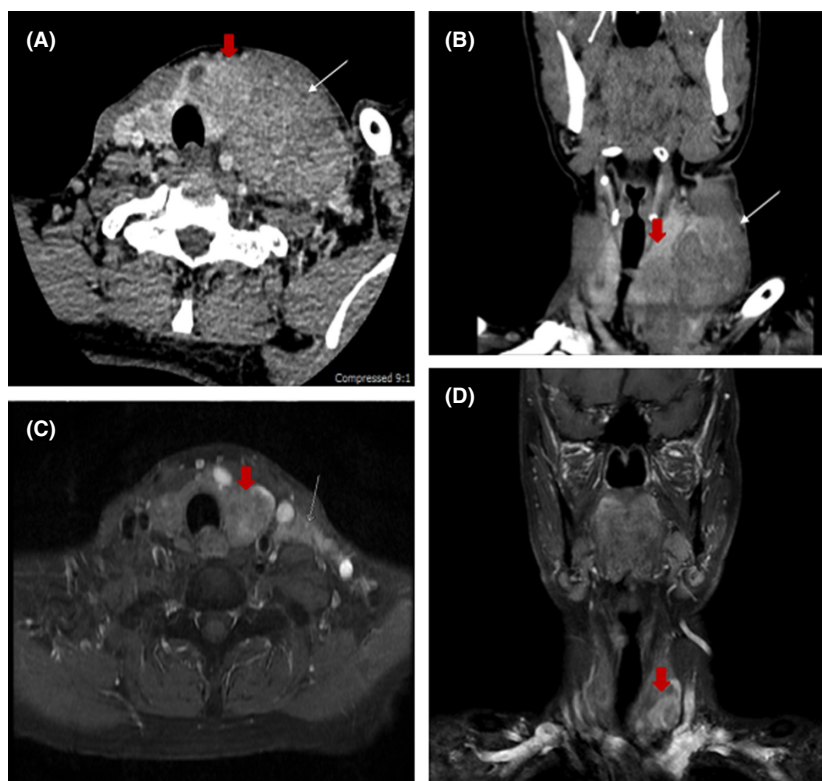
(A) Contrast CT scan of the neck; multiple hypoechoic nodules in both lobes of thyroid gland, with the largest nodules containing cystic component at lower pole of the left lobe (red arrow). (B) Multiple enlarged/matted lymph nodes (white arrow) of various sizes occupying along the left cervical level II–V, left supraclavicular region and left-sided superior mediastinum. (C) Postgadolinium axial T1FS after three-cycle chemotherapy; no significant change of thyroid nodules, the largest node at lower pole of the left lobe (red arrow) but (D) decreased size of the multiple enlarged matted lymph nodes (white arrow) along the left neck.
